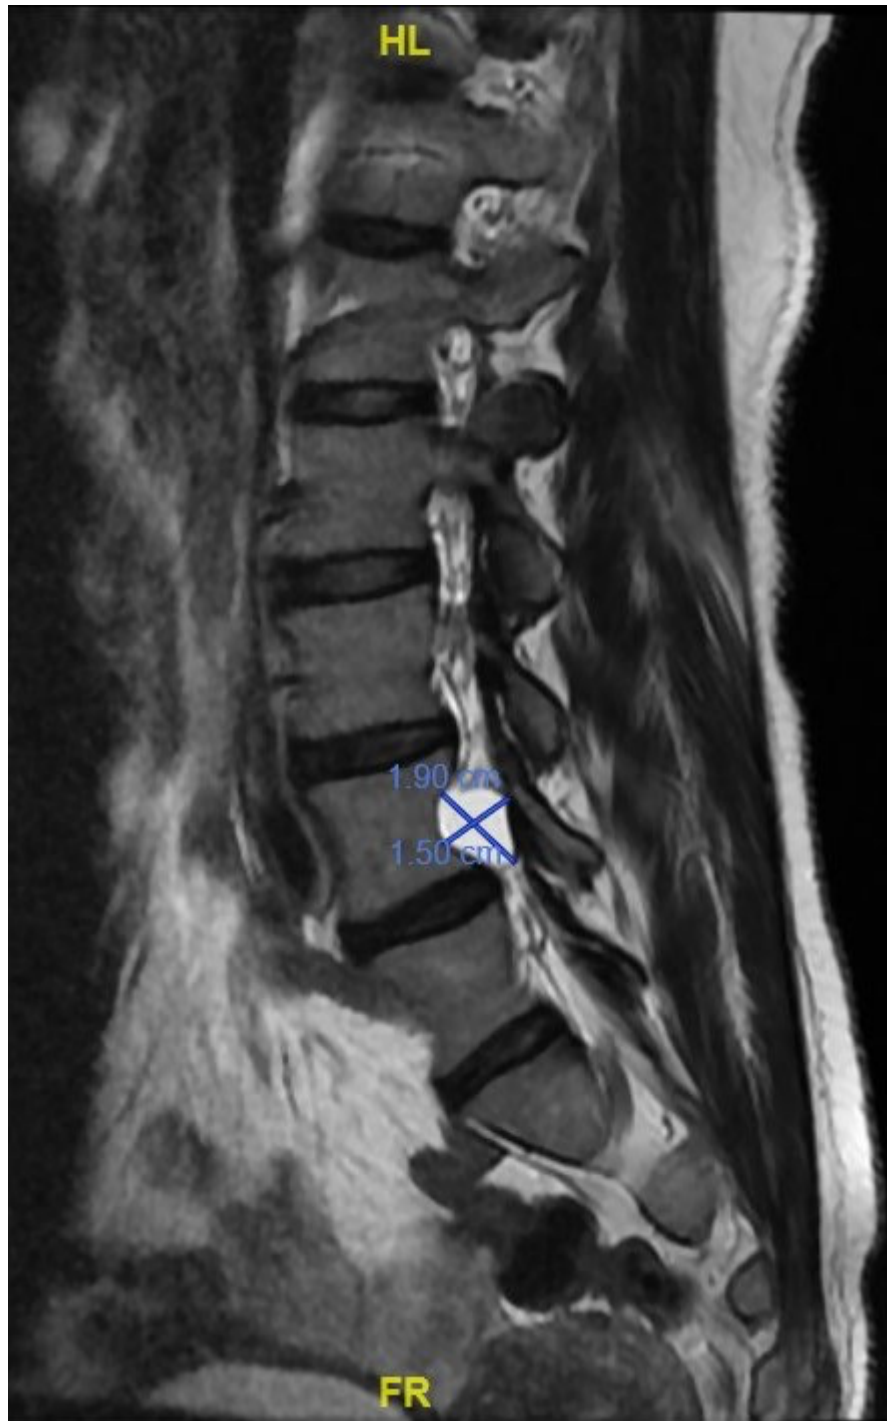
Sagittal T2-weighted image shows a L4 cystic lesion measuring 19×15 mm, causing mild compression of the adjacent right nerve root.
